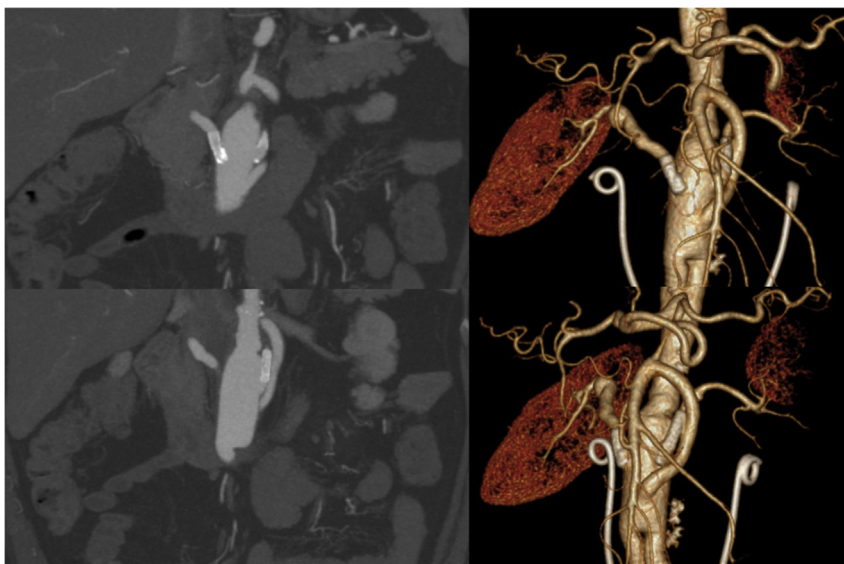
Computed tomography angiography showing patency of both stents.
